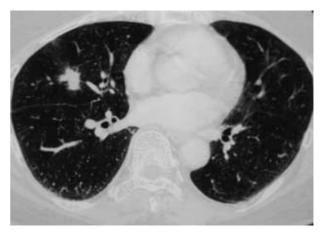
CT demonstrating a mass with unclear margins along the right B^4a bronchus.
